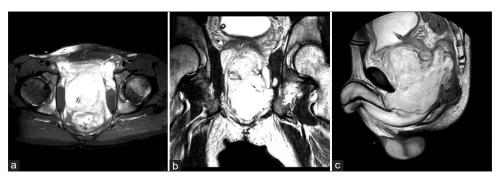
Magnetic resonance imaging (a, b, c) shows gross prostatomegaly with large lobulated T2 hyperintense heterogeneously enhancing mass lesion showing restricted diffusion, involving both lobes of the prostate with extraprostatic spread along anterior, posterior, and left lateral margins
